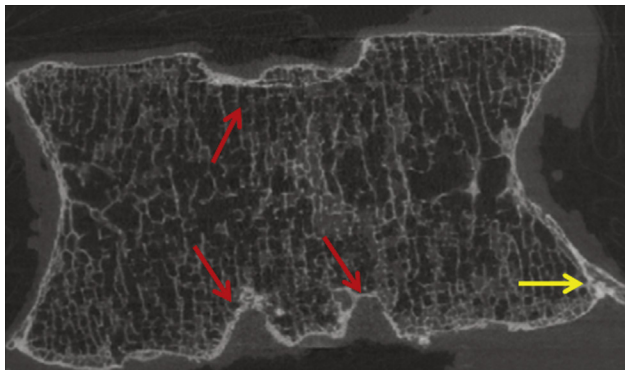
CT slice of an L1 vertebra. There are superior and inferior endplate fractures (shown by red arrows), all of which are likely to be chronic given the intact cortex. Notice the small osteophytes (yellow arrow) at the inferior endplate. A 3D reconstruction (not shown) confirmed these observations.
